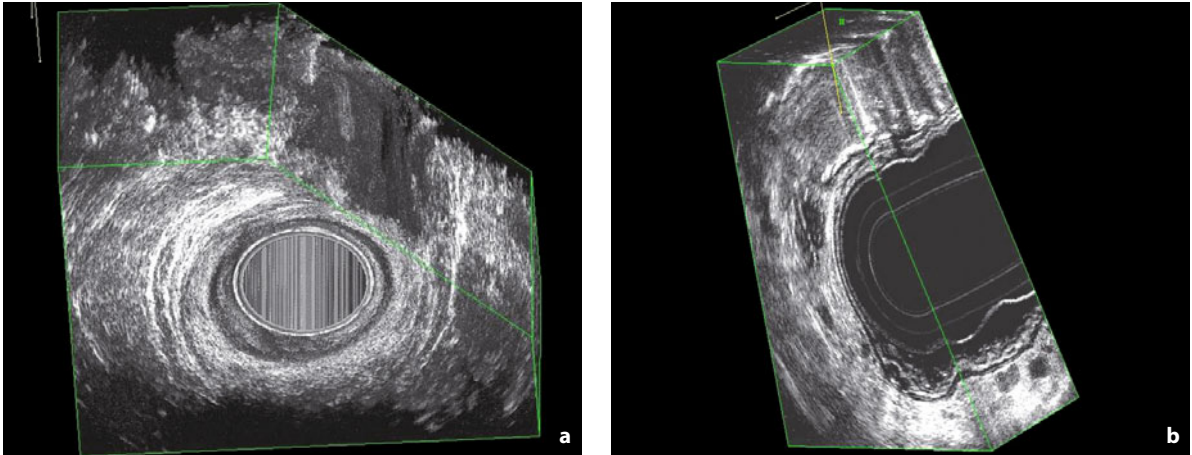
Three-dimensional endovaginal ultrasonography with multiplanar reconstruction: oblique sections (a, b). Images obtained using the 2050 probe (B-K Medical)
